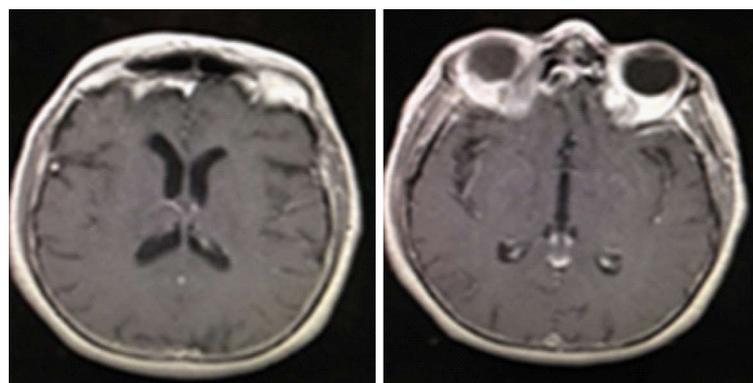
Magnetic resonance imaging performed 14 mo after surgery.
